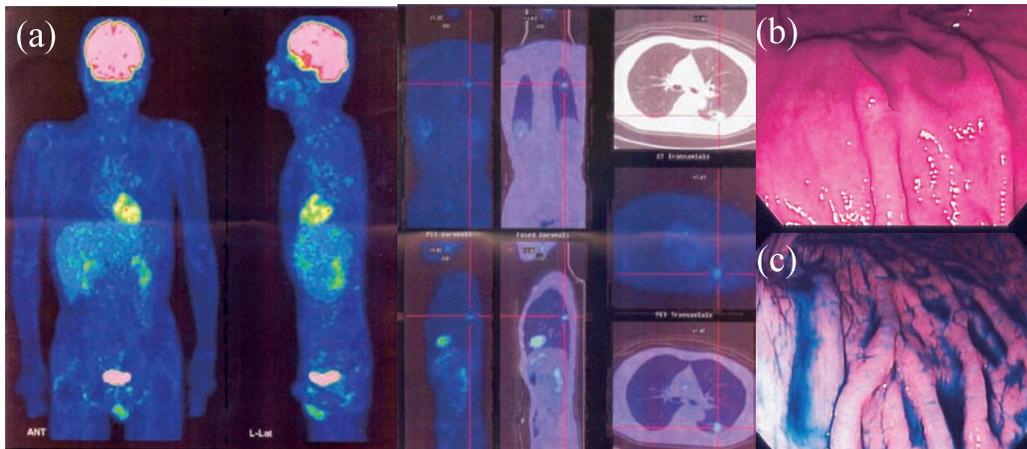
Positron emission tomography/computed tomography (PET/CT) and gastrointestinal endoscopy (GIS) findings after methotrexate withdrawal. *(2a)* PET/CT showing nonuptake in previously uptaking lesions except for the lesions of nontubercular mycobacteria in left lung. *(2b & 2c)* GIS findings of the stomach revealing resolution of the swelling in the upper portion of the gastric body and ulcer with reddish swelling on the gastric fundus.
